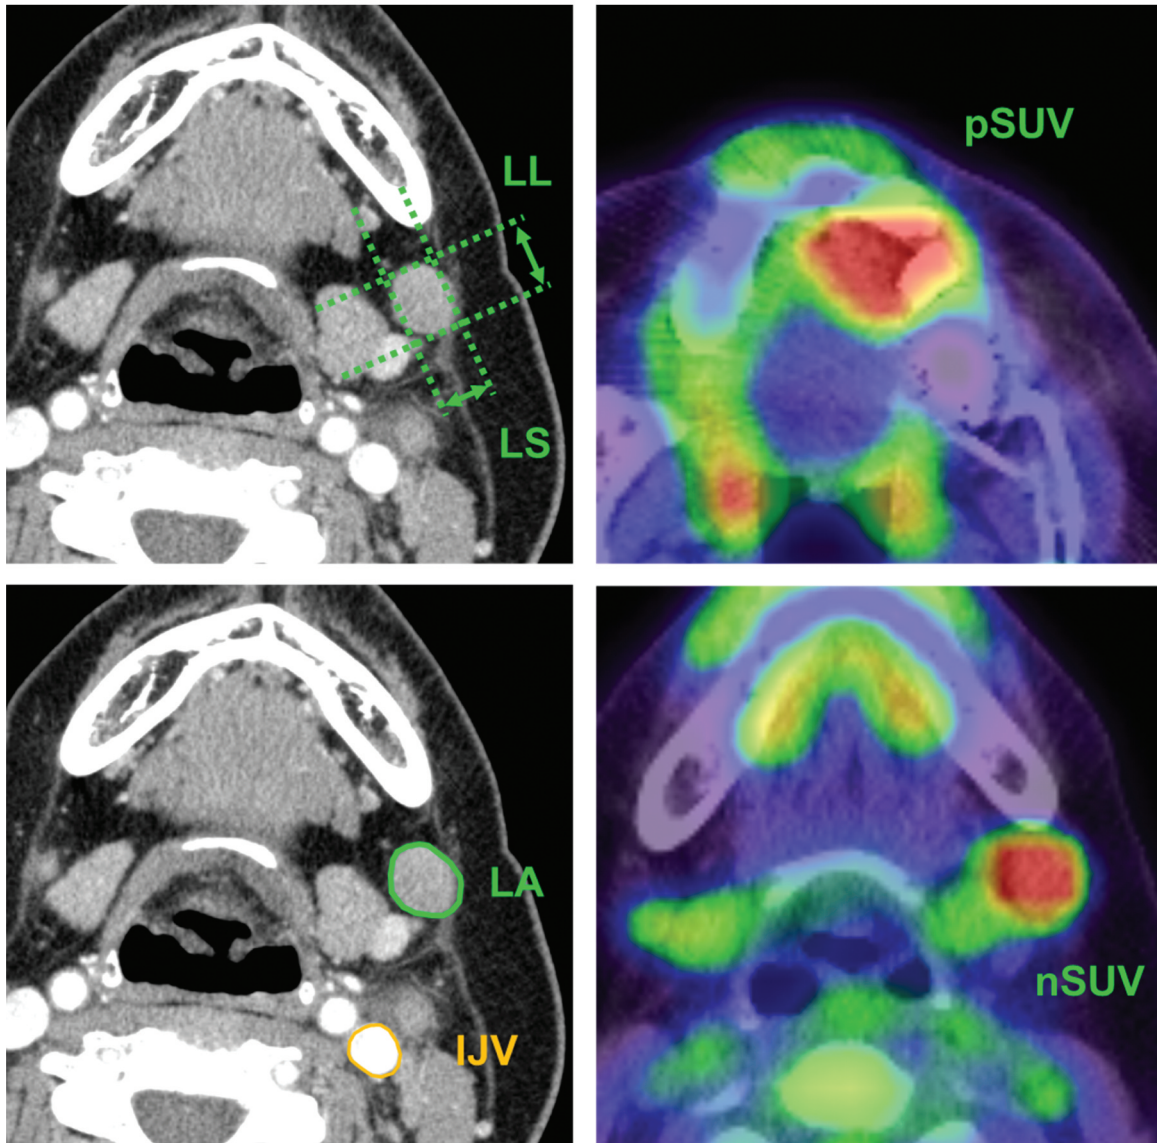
Measurement technique using preoperative computed tomography (CT) and 18-F fluorodeoxyglucose-positron emission tomography/CT images. IJV: Internal jugular vein; LA: the area of the target cervical lymph node (CLN); LCT: the relative CT value of the target CLN calculated based on the CT value of the IJV; LL: the longest diameter of the target CLN; LS: the shortest diameter of the target CLN; nSUV: the SUVmax of the target CLN; pSUV: the SUVmax of the primary tumor.
